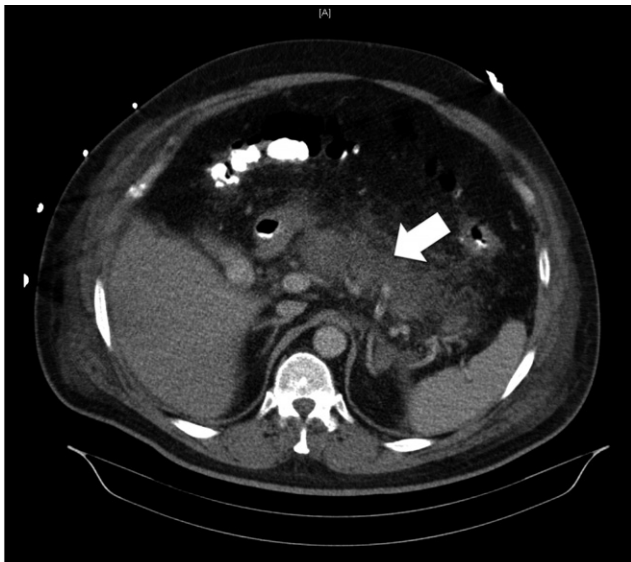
Contrast-enhanced CT scan on hospital day 1 demonstrating interstitial pancreatitis (arrow).
